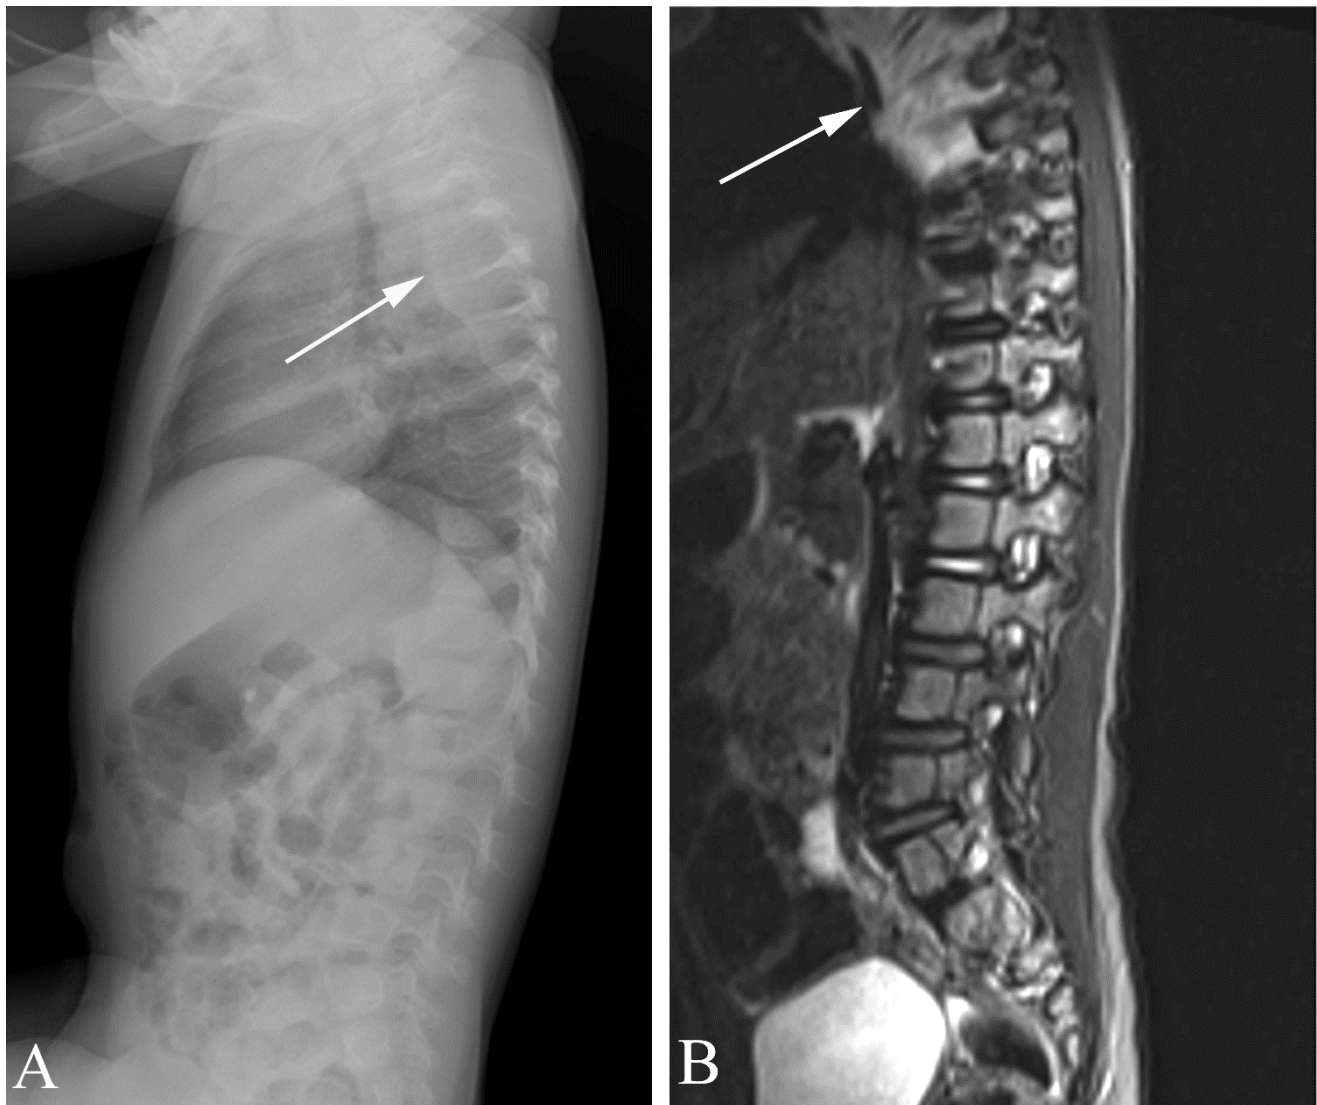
Neuroblastoma in a 2 year old with back pain, fatigue, and fussiness. A. Lateral plain film of the lumbar and thoracic spine shows a mass (arrow) along the posterior upper chest. B. Sagittal T2 MR shows a paraspinal mass (arrow).
